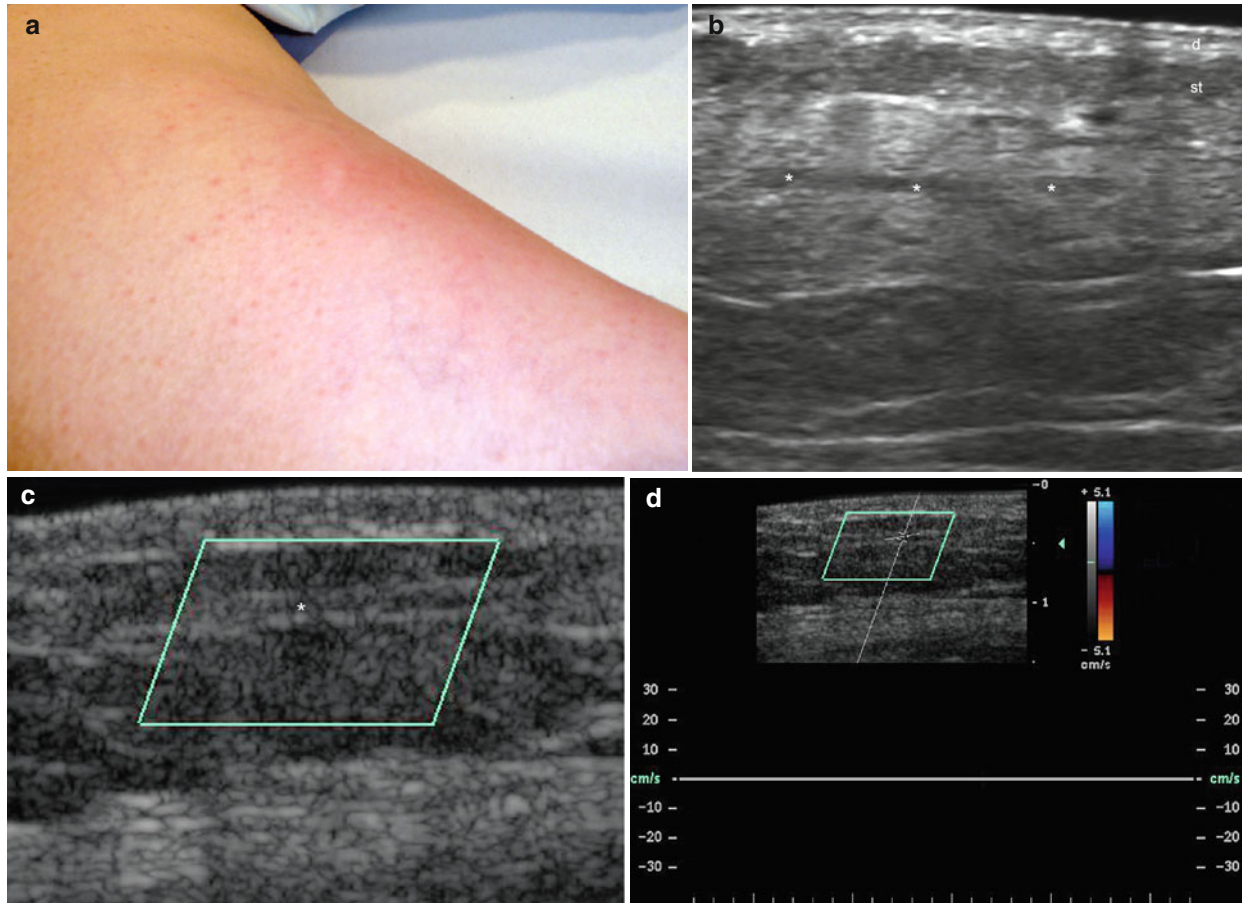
(a–d) Mondor's disease. (a) Clinical image shows erythema in the medial aspect of the right thigh. There was also a palpable cord-like structure. (b) Gray scale ultrasound image (longitudinal view) demonstrates a dilated vessel in the subcutaneous tissue filled with hypoechoic thrombotic material (*). Increased echogenicity is detected
